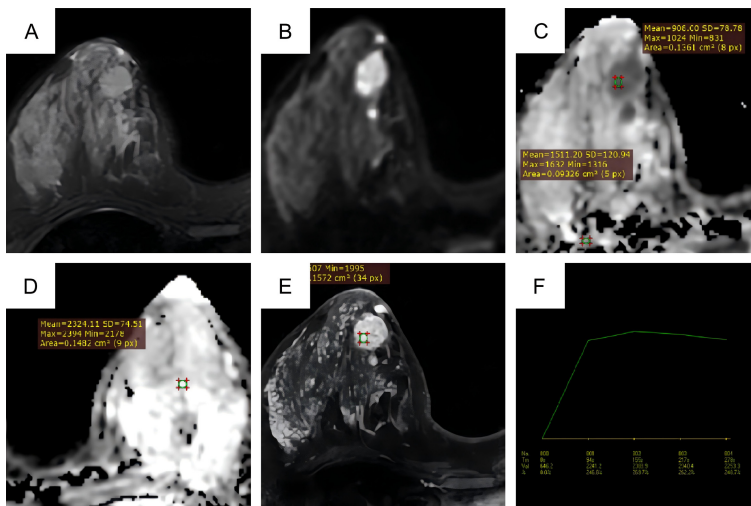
Representative images of a 26-year-old woman with non-TNBC (Luminal B subtype). A. Axial fat-suppressed T2-weighted image reveals an oval-shaped mass with isointensity, demonstrating the absence of cystic necrosis and peritumoral edema. B. Diffusion-weighted imaging (DWI) demonstrates high signal intensity. C. On the ADC map, the mean ADC value is $0.908 \times 10^{-3} \text{ mm}^2/\text{s}$, and the rADC1 (lesion/pectoralis major muscle) is 0.50. D. On the ADC map, the rADC2 (lesion/contralateral normal gland) is 0.39. E. Early-phase DCE-MRI exhibits heterogeneous enhancement. F. The time-intensity curve (TIC) shows a plateau pattern (Type II).
